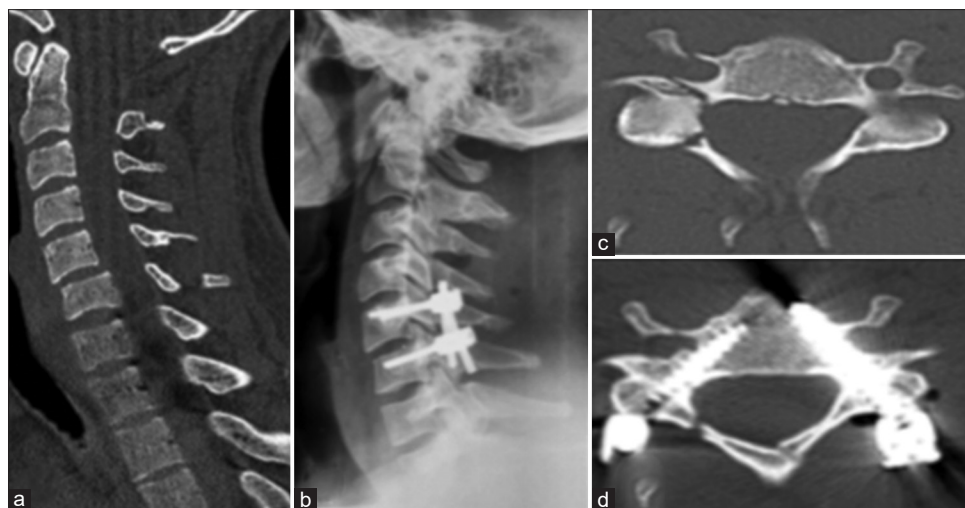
Male, 28-year-old. Dive in shallow water. AO Spine C5-C6 C F4 N1. Frankel E, paresthesia in C6 territory on the right. Tomography showing fracture-dislocation C5-C6 (a) with a floating lateral mass at C5 on the right (c). Bilateral C5-C6 pedicle fixation was performed with reduced dislocation. The axial CT section demonstrates the path of the pedicle screws at the level of C5, with compression of the interfragmentary on the right (d) promoting stability, associated with monosegmental arthrodesis (b). CT: Computed tomography
